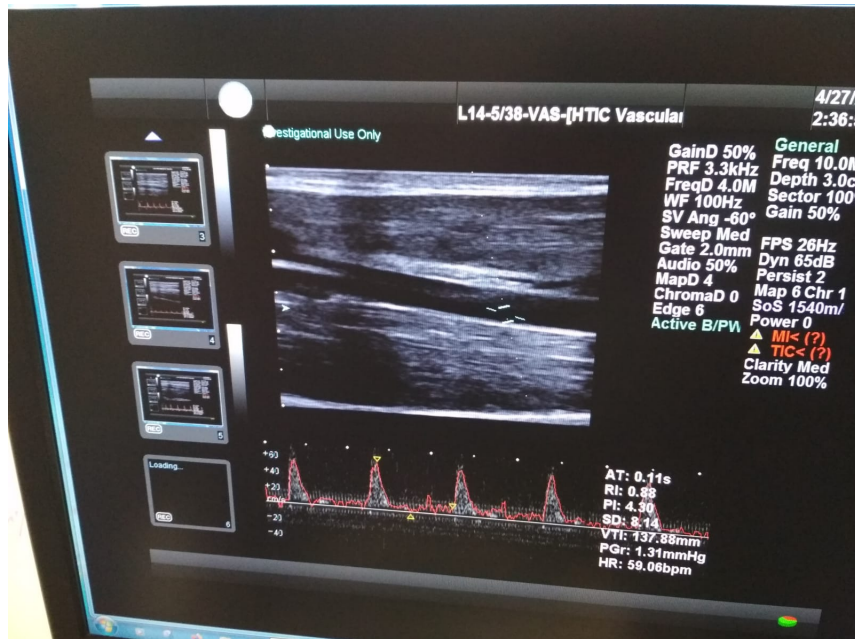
Ultrasonix screen during FMD experiment
